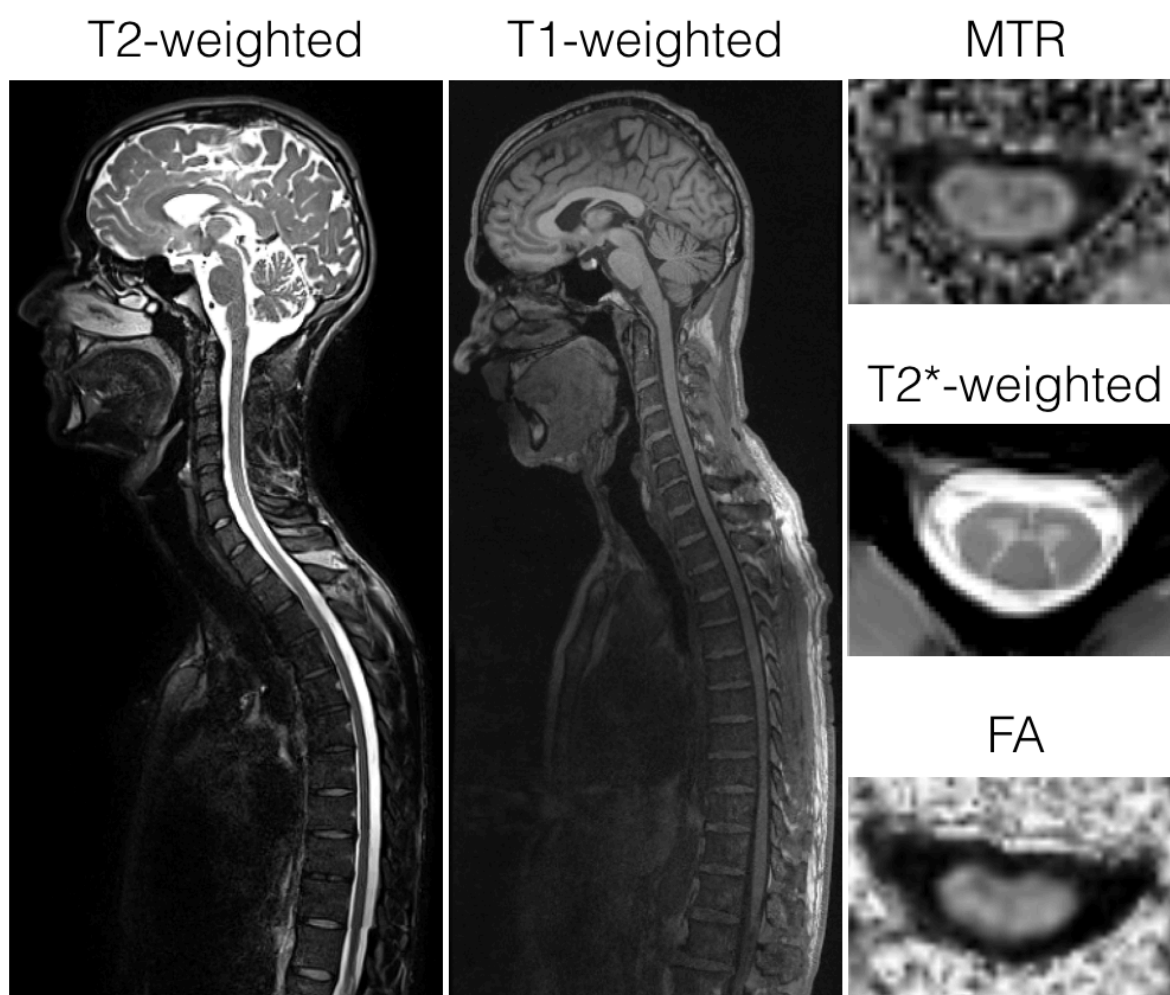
Example of MRI contrasts from multi-parametric MRI, including T1-, T2- and T2*-weighted images and magnetization transfer ratio (MTR) and fractional anisotropy (FA).
